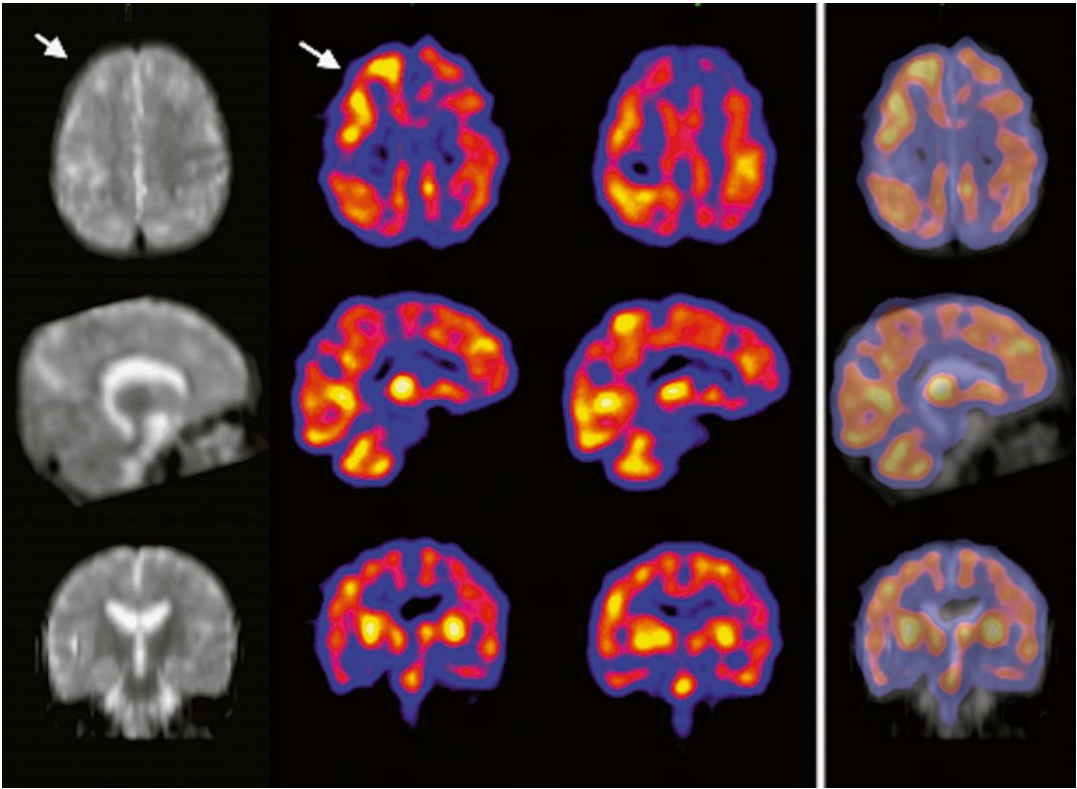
Three-year-old boy with tuberous sclerosis and intractable seizure disorder. The MRI shows multiple tubers. The interictal ^{99m}Tc -ECD perfusion SPECT
